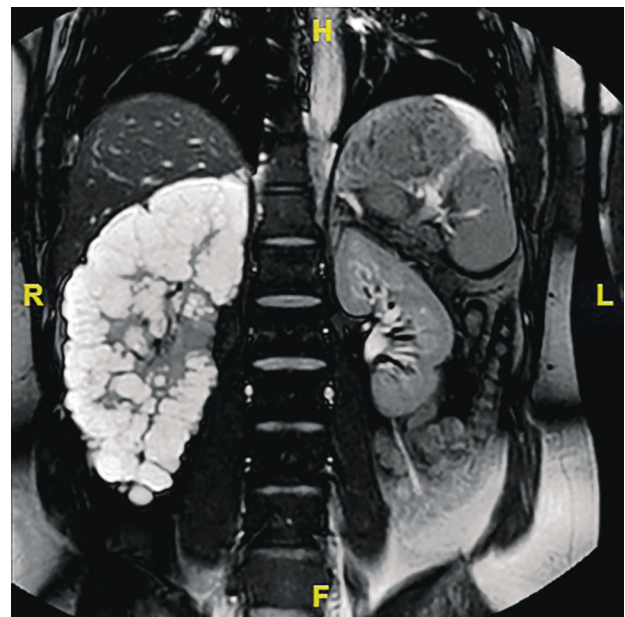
Axial T2-weighted MR images show unilateral multiple cysts in the right kidney. Note that majority of the cysts are located peripherally consistent with lymphangiomas.
